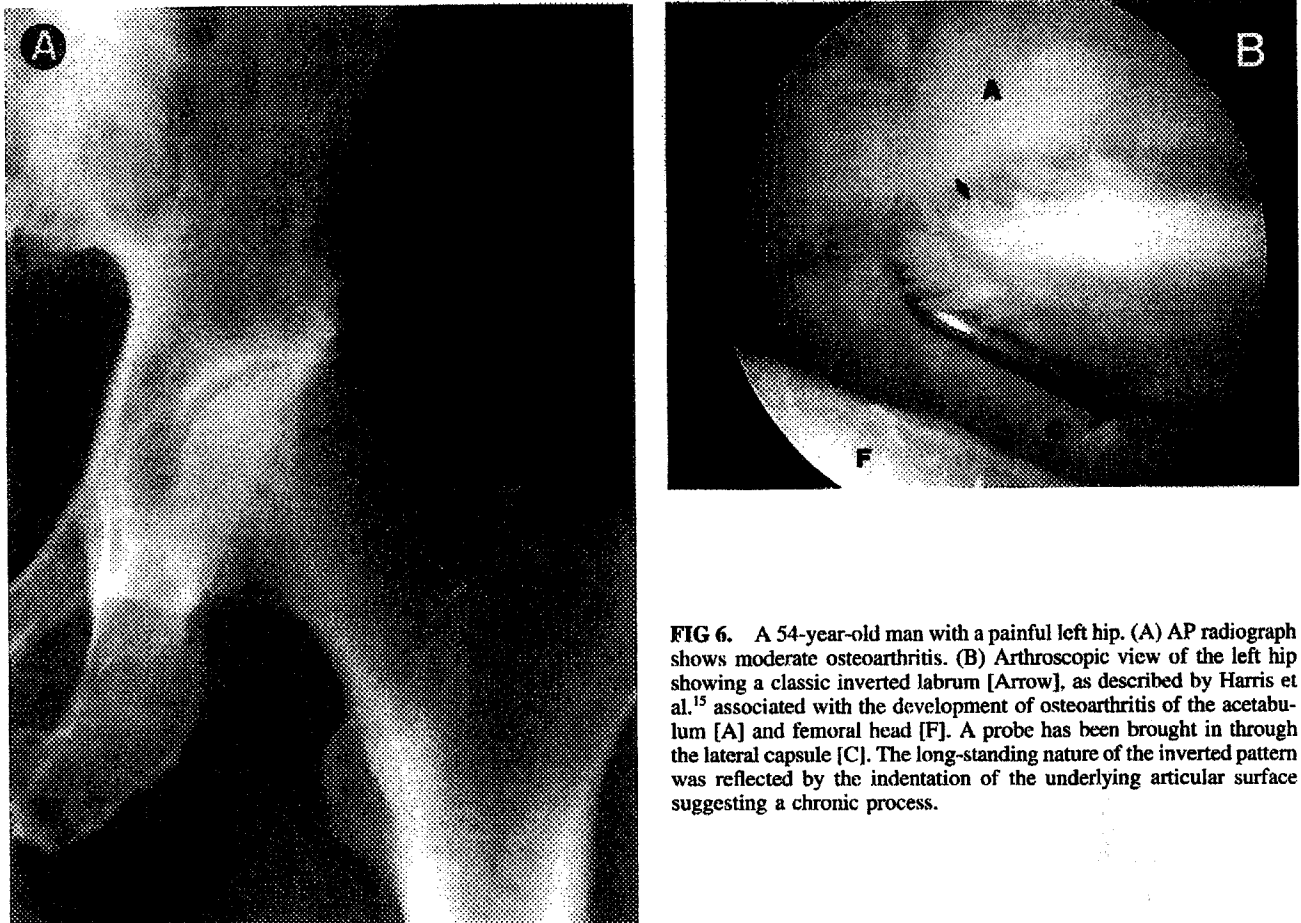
A 54-year-old man with a painful left hip. (A) AP radiograph shows moderate osteoarthritis. (B) Arthroscopic view of the left hip showing a classic inverted labrum [Arrow], as described by Harris et al.¹⁵ associated with the development of osteoarthritis of the acetabulum [A] and femoral head [F]. A probe has been brought in through the lateral capsule [C]. The long-standing nature of the inverted pattern was reflected by the indentation of the underlying articular surface suggesting a chronic process.
